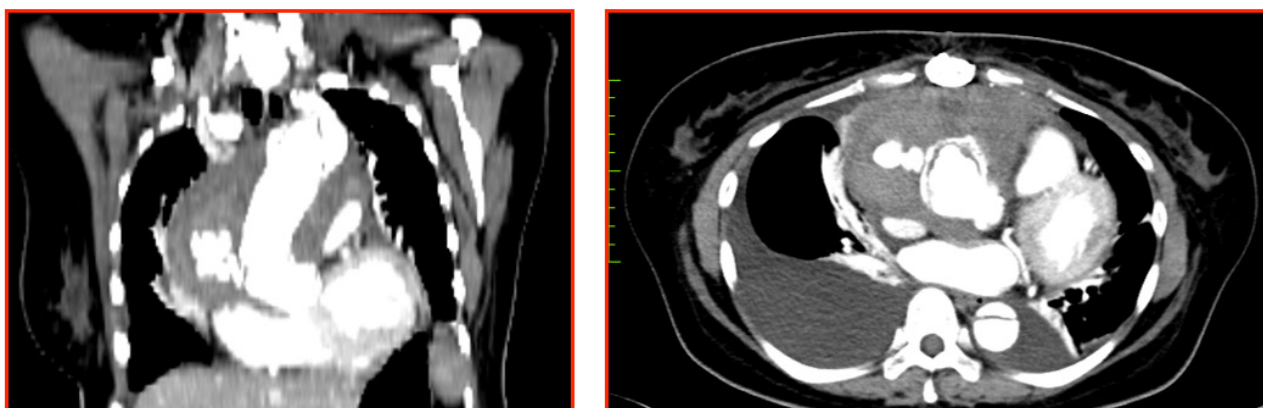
Coronal reconstruction(left) and axial view (right) of CT angiogram aorta which showed contrast extravasation.
